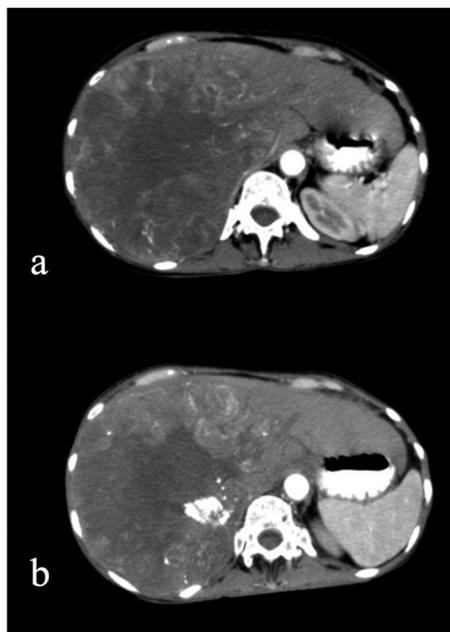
CT Scan of a 62 years old female with HCC BCLC B, (a) before TACE procedure, b) after, conclusion from before and after image was increased necrotic area, with decrease viable tumour, shown as decrease of tumour vascularisation and enhancement on the solid part, as well as lipiodol retention, even though the same tumor size.
